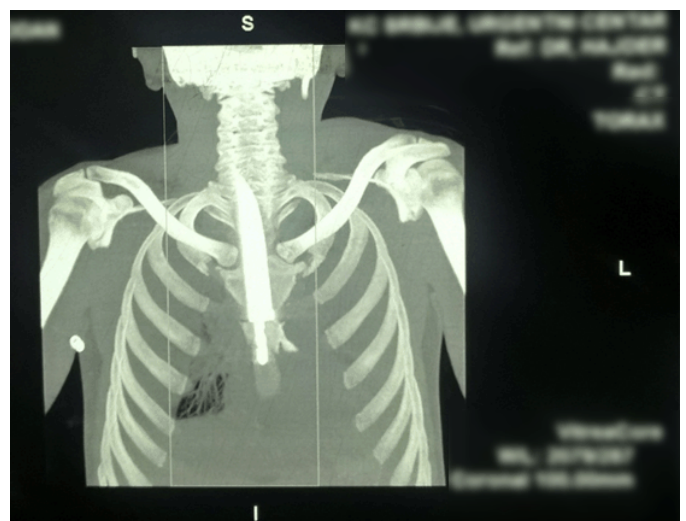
Computed tomography (CT) of the chest.
